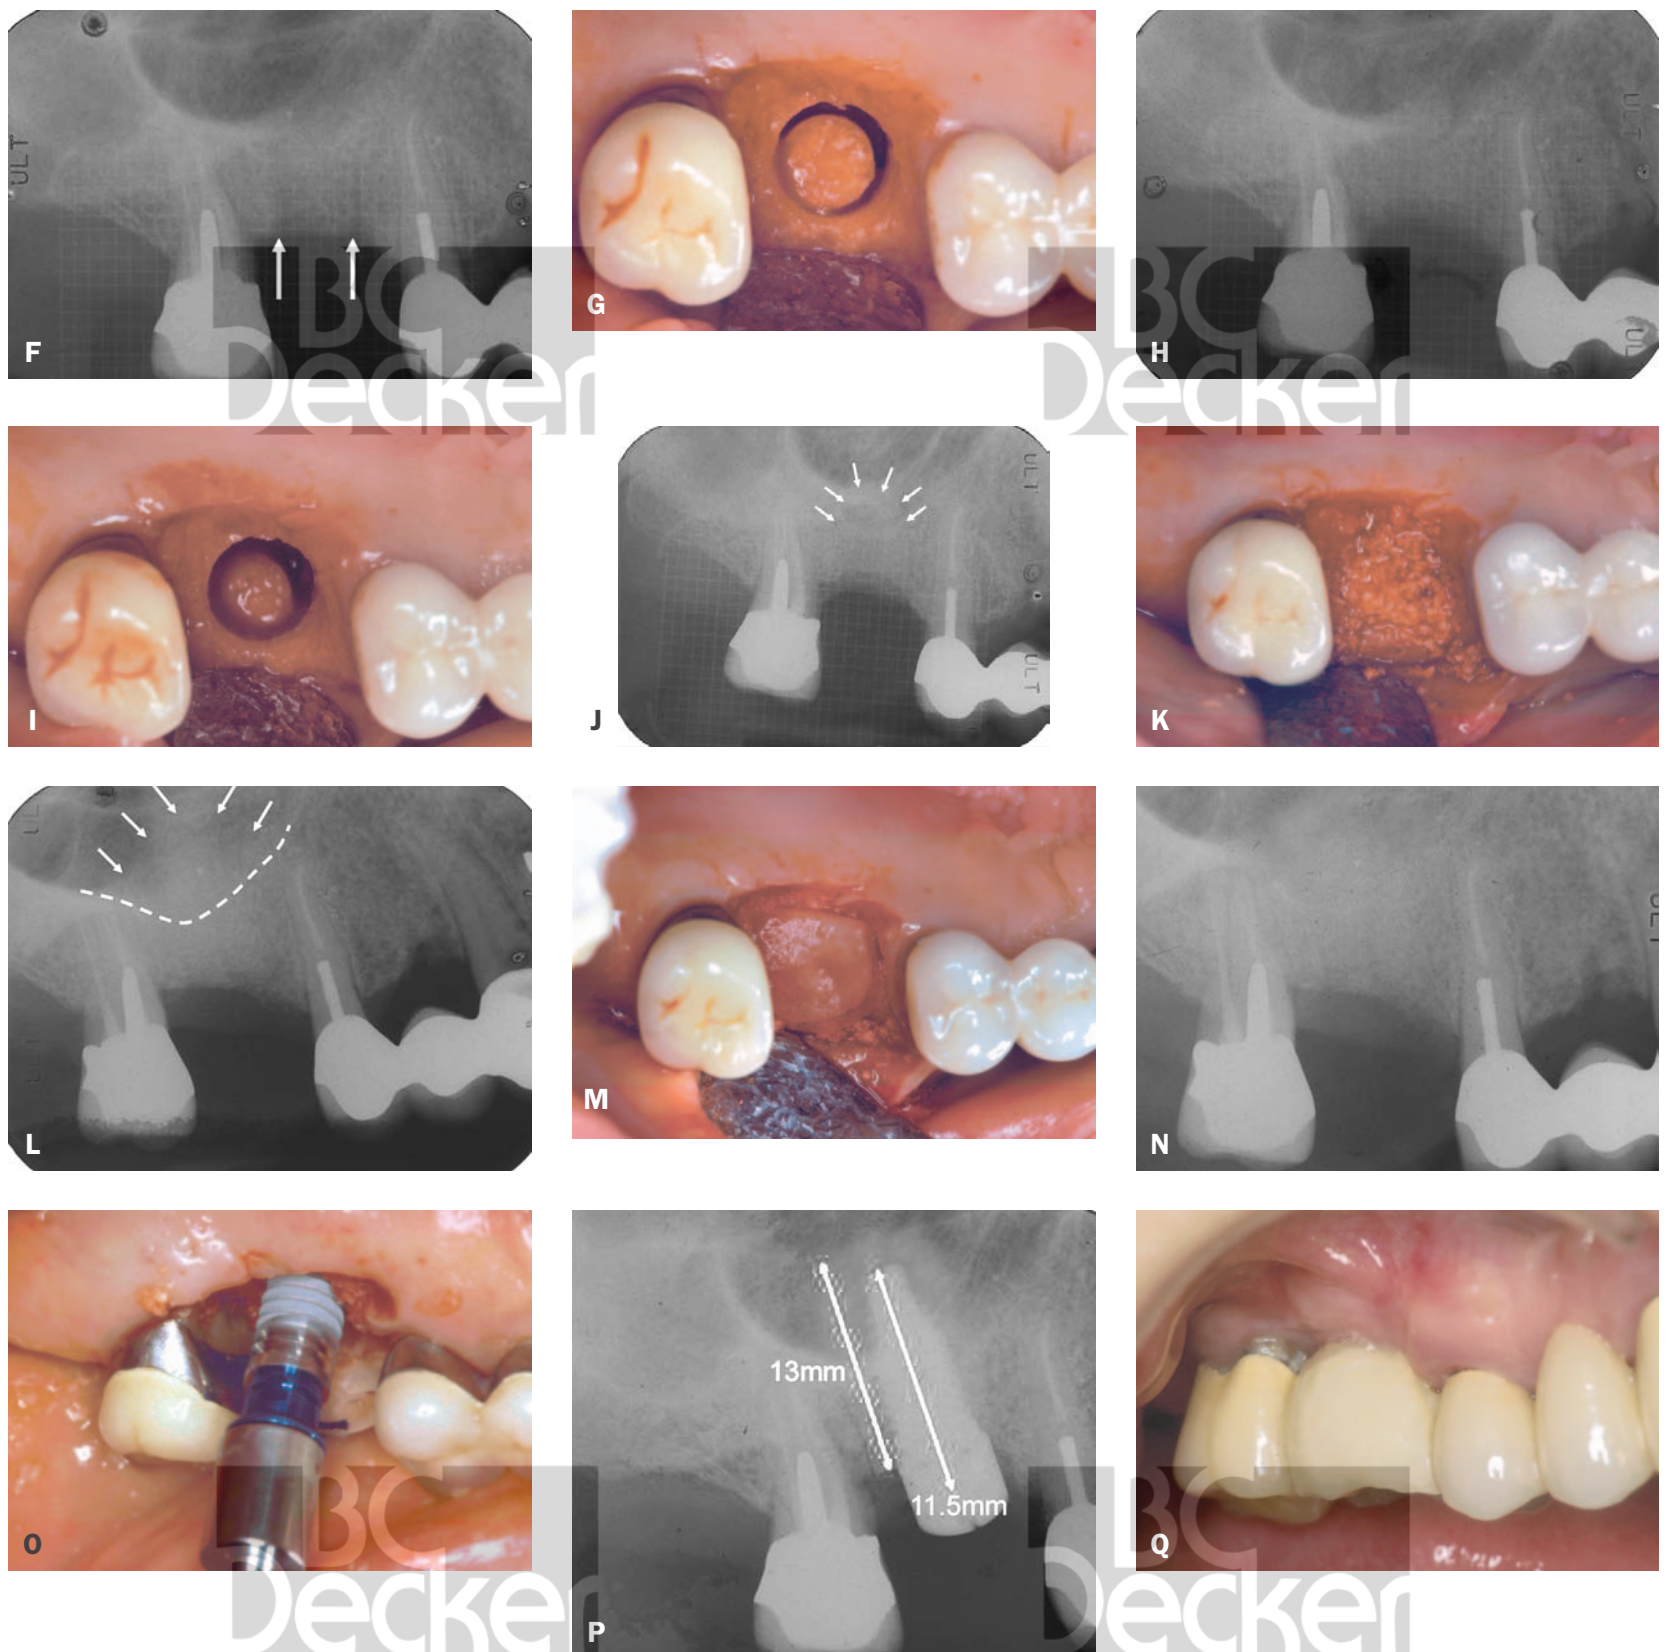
Continued.* F, Radiograph showing vertical bone cuts. G, Initial infrafracture of the bone core. H, Radiograph of the initial infrafracture of a bony plug. I, The bone core completely freed and the sinus floor elevated. J, Radiograph showing complete infrafracture of the bony core. K, Graft material added to the defect. L, Radiograph of the grafted sinus. M, Flap reposition prior to suturing. N, Radiograph 8 months later. Note increased bone height. O, Implant placed (11.5 × 5 mm Osteotite, 3I). P, Radiograph of the implant with healing abutment. Q, Implant temporized for 3 months for progressive loading.
